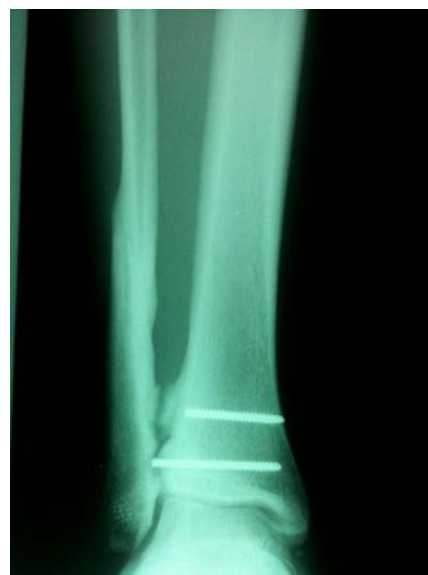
Radiograph revealing broken syndesmotic screws from previous surgery and fractured heterotopic ossification of the syndesmosis.
